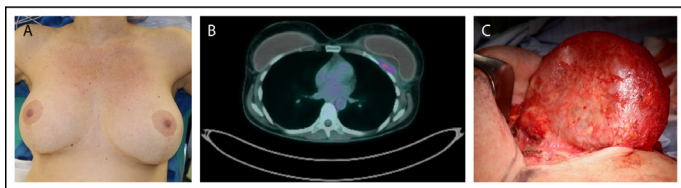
BIA-ALCL following breast reconstruction using silicone breast implants. (a) An image taken 7 years after cosmetic breast augmentation with bilateral textured breast implants. (b) Perioperative computerised tomography (CT) scan showing posterior capsule wall mass invading the chest wall (shown in pink). (c) Image showing a total capsulectomy with excision of skin involvement to ensure that any residual disease is removed and to reduce risk of disease progression. Republished with permission of Elsevier Science & Technology Journals, from Mehta-Shah et al;¹⁷ permission conveyed through Copyright Clearance Center, Inc.
